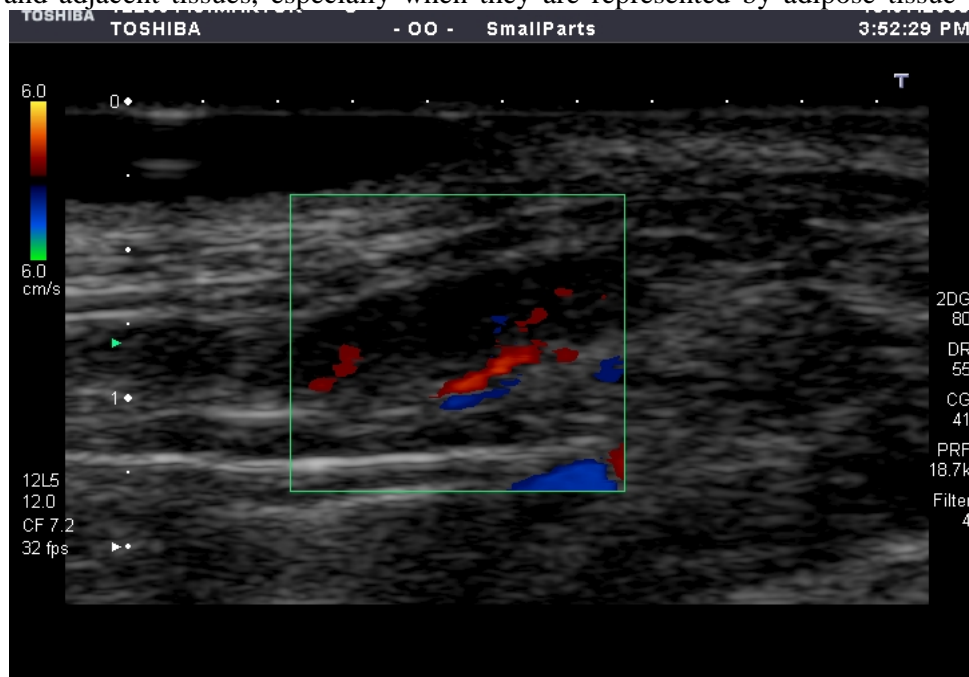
Assessing the direction and velocity of blood flow in superficial lymph nodes by color Doppler technique
